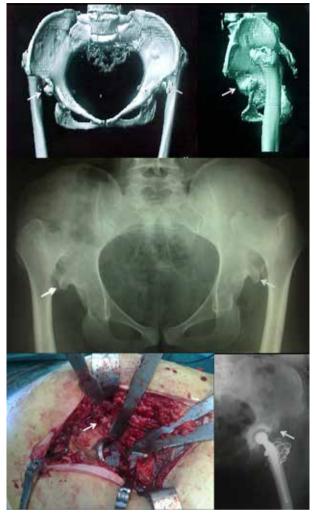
As a rule, in high dislocation there is an anterolateral bony prominence beside the inferior iliac spine (arrows). This prominence in the plain AP radiograph can give the false impression of adequate bone at the weight-bearing area to achieve good coverage of the acetabulum, and in postoperative radiographs the cup can look too much medialized. This bony prominence is too anteriorly to offer any reliable anterosuperior support to the cup.
